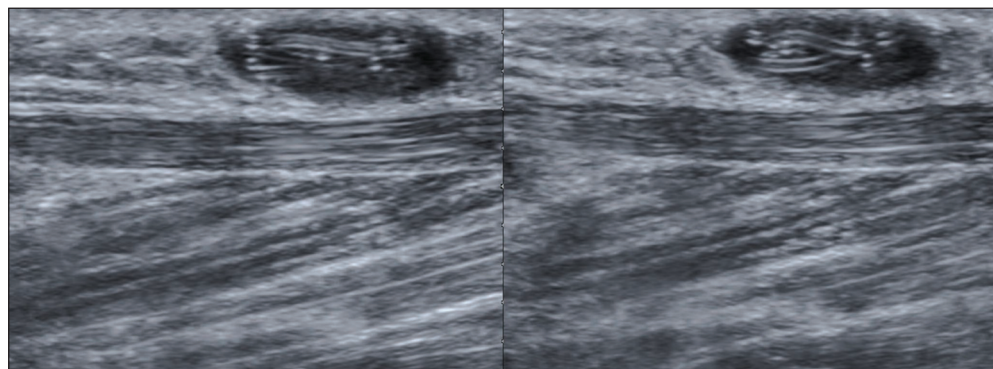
Ultrasound appearance of subcutaneous change
